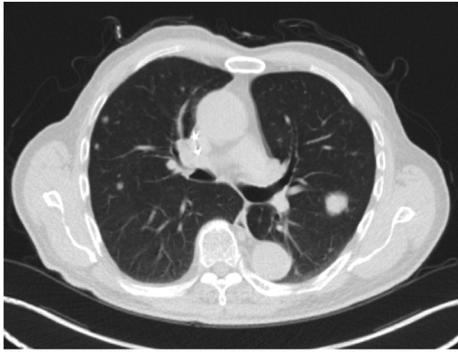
Axial computed tomography image of chest showing bilateral well-circumscribed lung nodules. Biopsy consistent with metastatic ductal adenocarcinoma.
